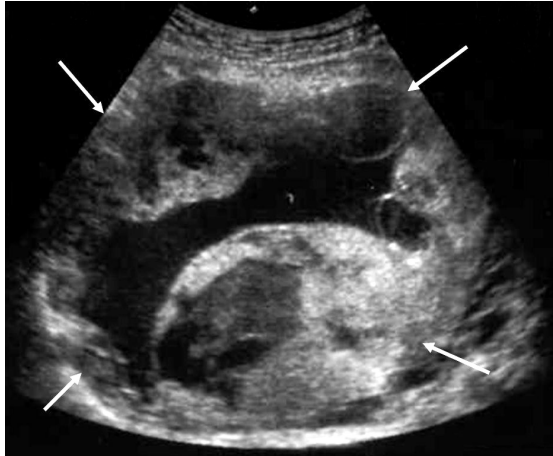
Transabdominal ultrasonography image of the pelvis shows a mass (white arrows). The uterus and ovaries (not shown) were normal.
